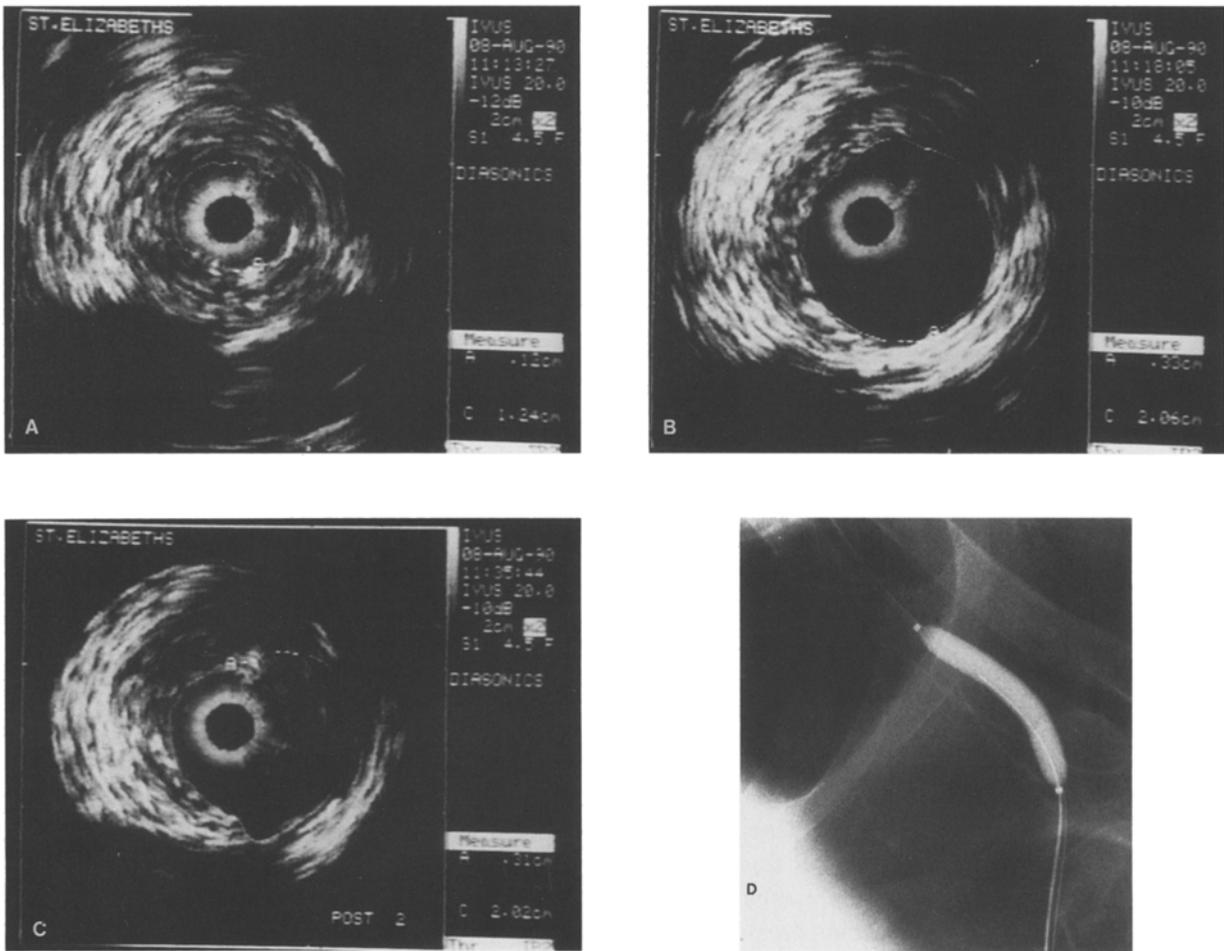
A, BUIC pre-inflation in left iliac artery ($XSA = 0.12 \text{ cm}^2$). B, At full inflation. Real time images showed a sudden increase in luminal area at about 2 Atm. Relative movement of flap end (6 o'clock), noticeable as balloon inflated. (Maximum inflated area = 0.33 cm^2). C, Post-PTA image through deflated balloon ($XSA = 0.31 \text{ cm}^2$). D, Asymmetric position of the imaging transducer in X-ray of fully inflated BUIC.
